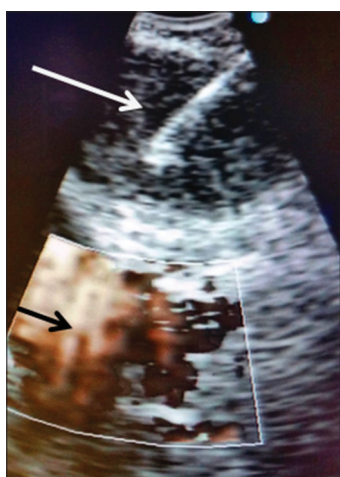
The image shows needle inserted in subcarinal lymph node under ultrasound guidance (white arrow) and vascular structure detected by Doppler (black arrow)
